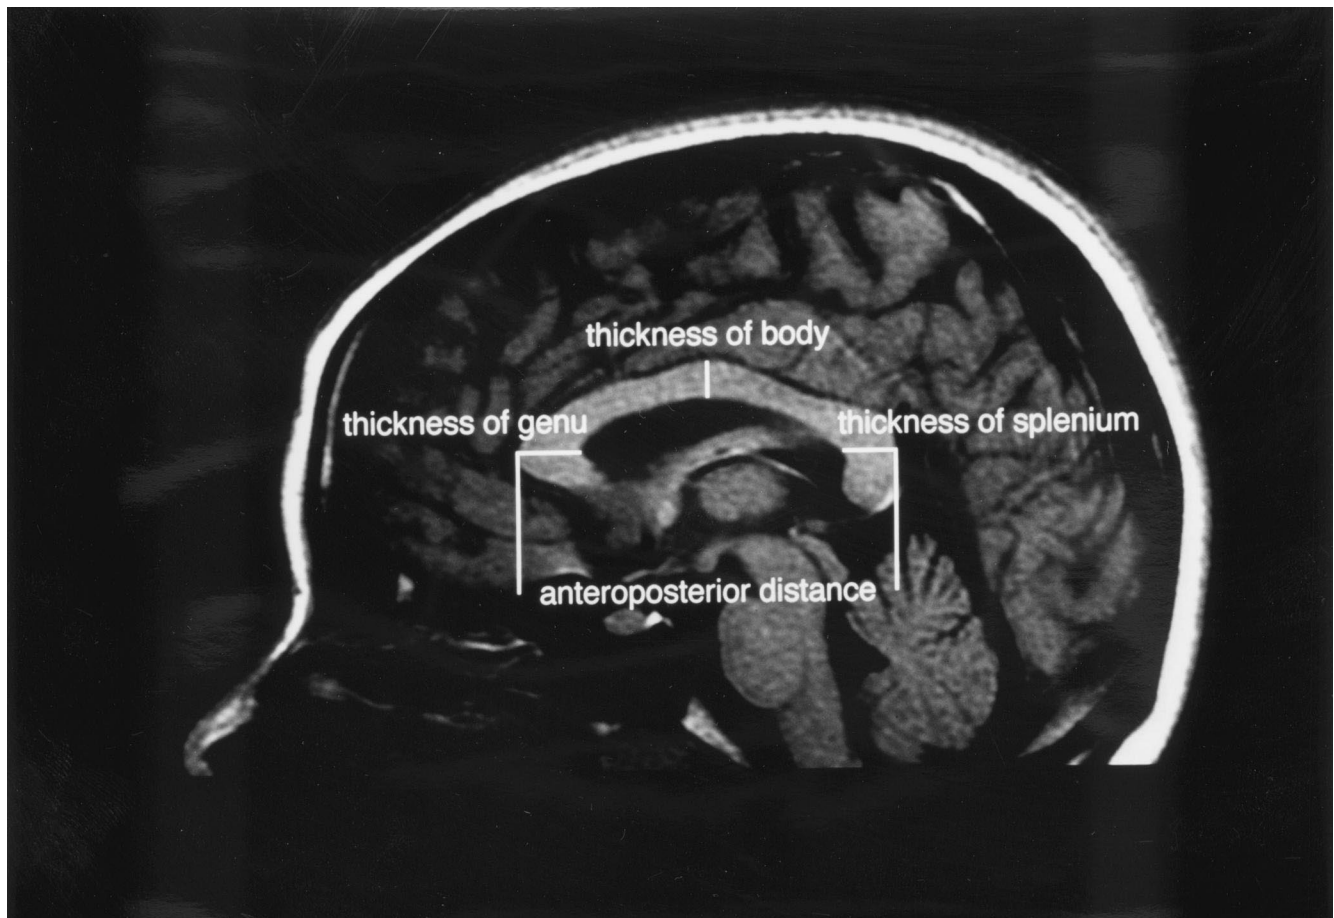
The sagittal plane of T1-weighted image of head magnetic resonance imaging (MRI). The corpus callosum area, the anteroposterior distance, the thickness of the genu, the thickness of the body, and the thickness of the splenium were measured.
